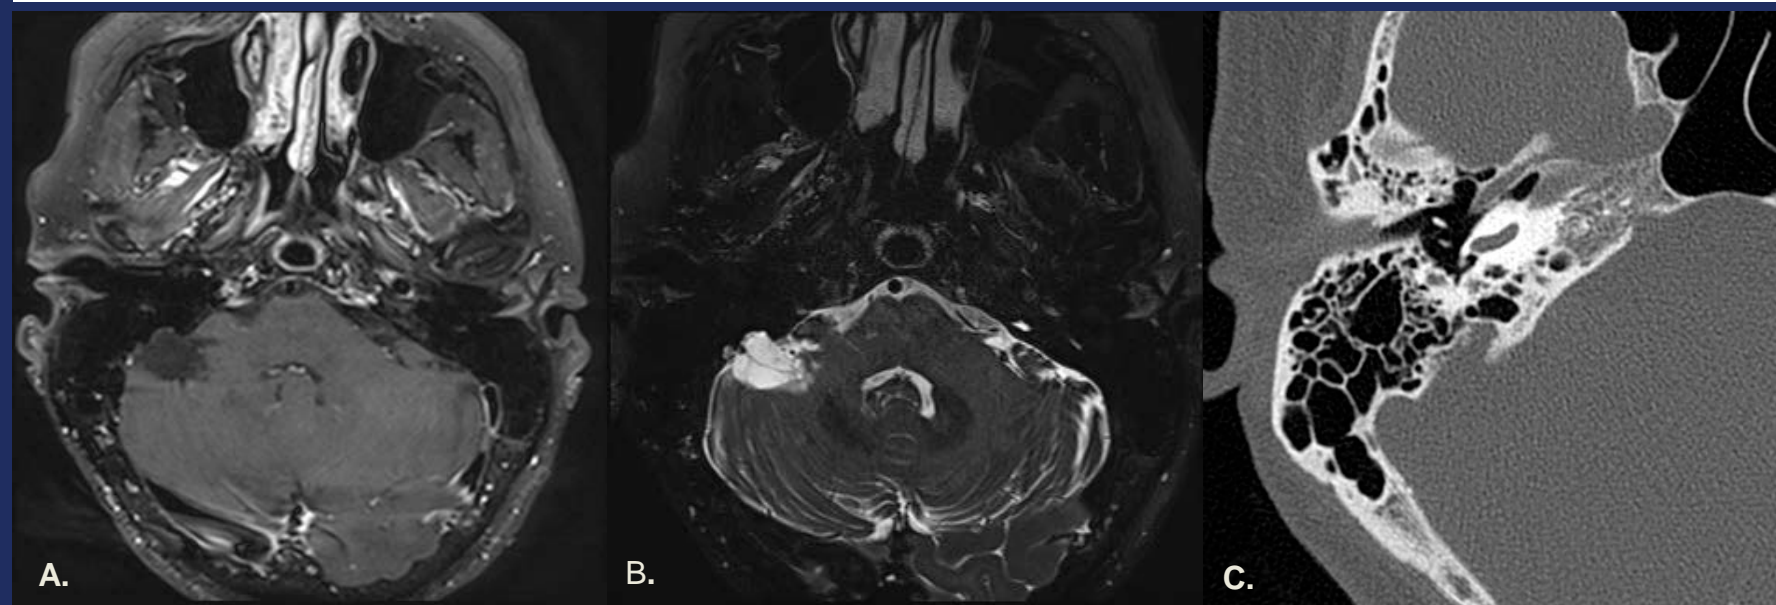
Case #1 of a pathologically-confirmed posterior temporal bone arachnoid granulation. (A) Gadolinium-enhanced fat-suppressed axial T1-weighted image demonstrates a nonenhancing, extra-axial mass that is isointense to CSF and extends through the posterior cortex of the right temporal bone. (B) High-resolution fat-suppressed axial T2-weighted sequence demonstrates the mass to be isointense to CSF. (C) High-resolution axial CT of the right temporal bone confirms bony erosion of the posterior wall, without bone spicules.
